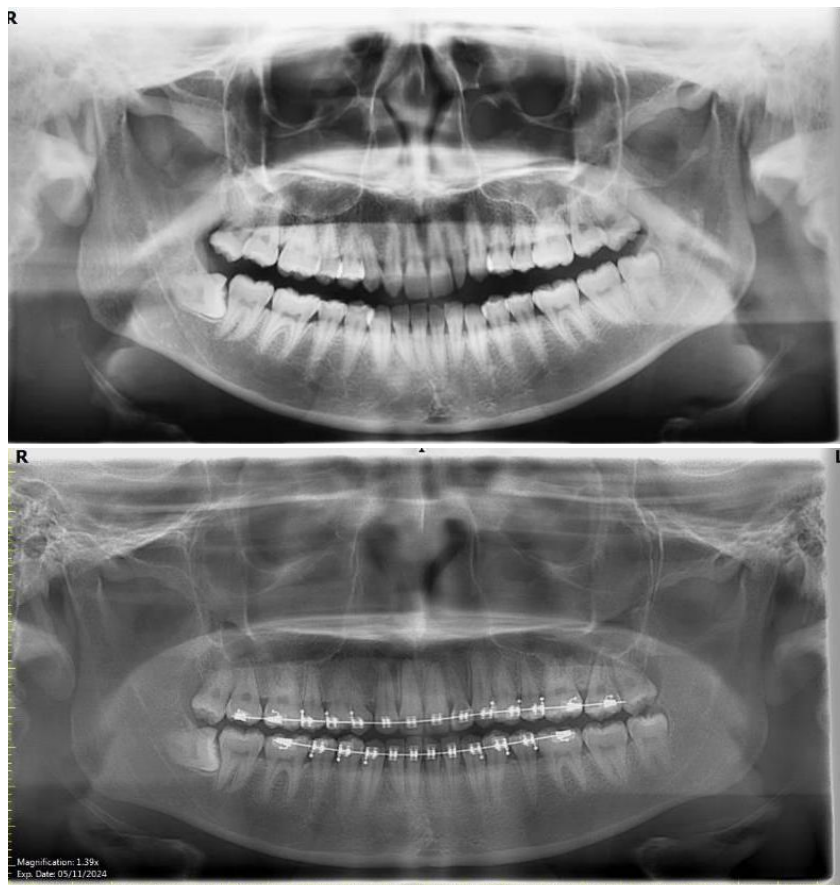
Panoramic radiograph before and after treatment
